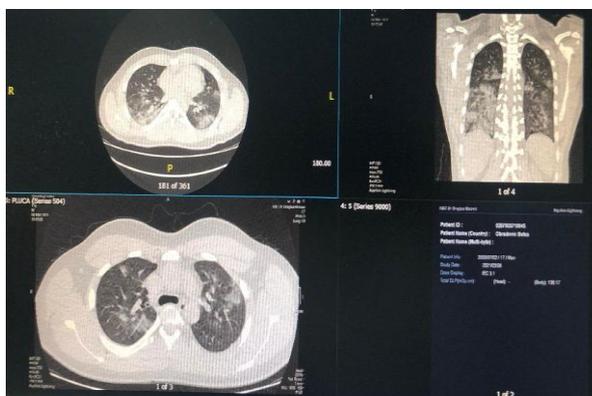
CT nalaz kod 13 godina stare djevojčice (CT skor 22/25)
